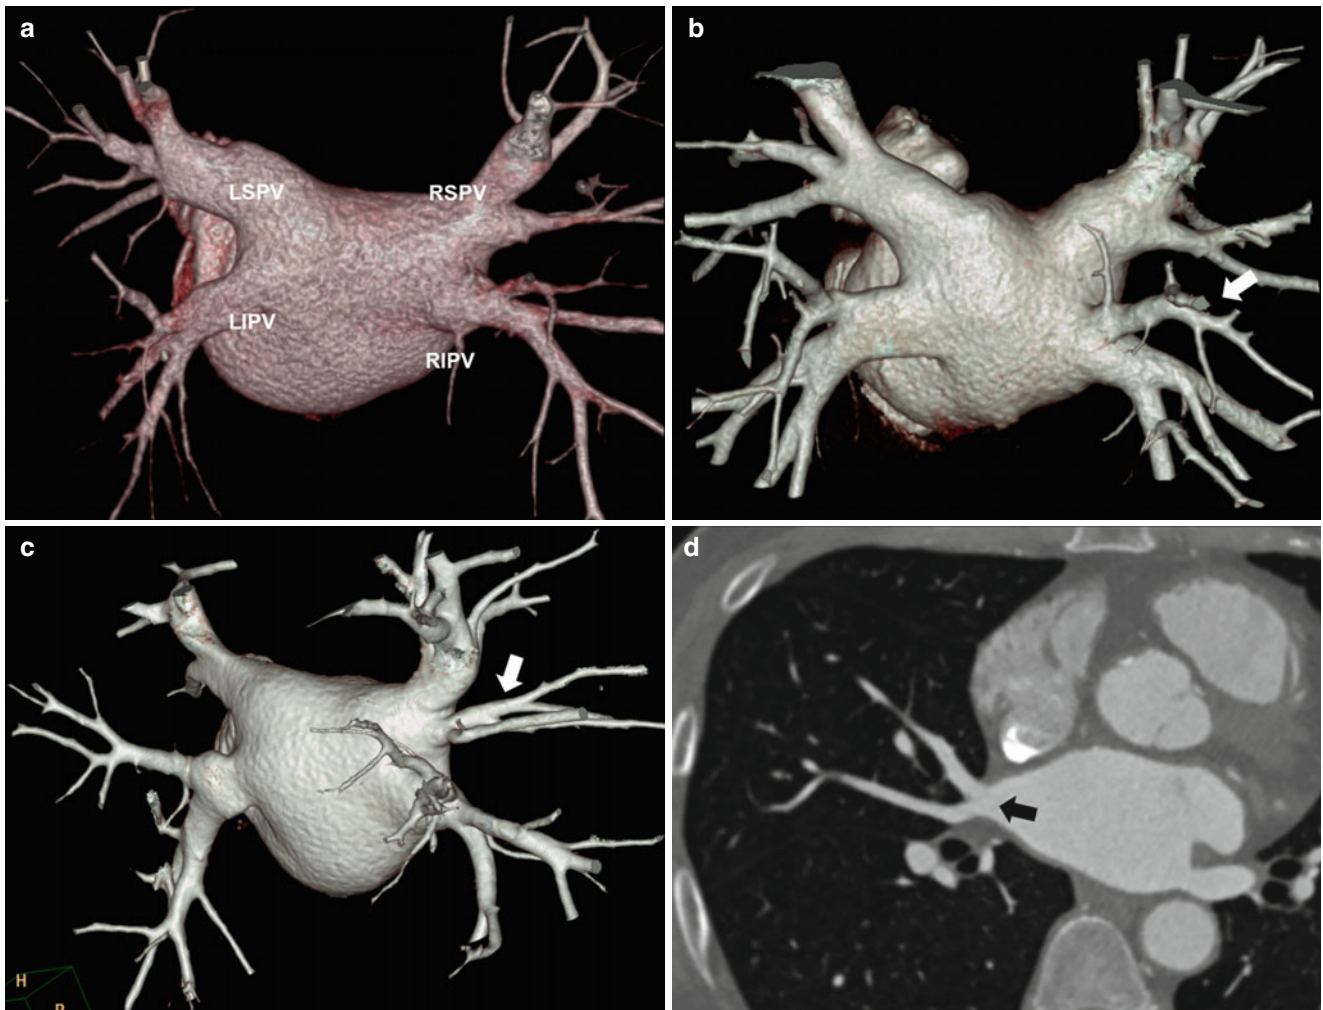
Anatomy of the pulmonary veins. Three-dimensional CT images show normal appearance and anatomic variants of the pulmonary veins: (a) normal appearance, (b) an early branching of the pulmonary vein (ostial branch, *arrow*), and (c, d) a small right middle
